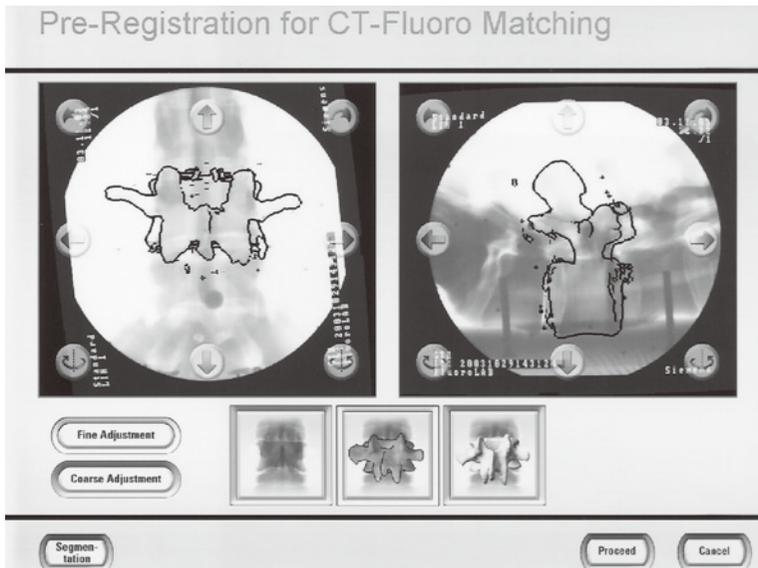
Pre-registration for CT-fluoro matching. Segmented vertebra is positioned over AP and lateral fluoroscopic images. Matching segmented vertebra as closely as possible to corresponding vertebra in fluoro image ensures best possible registration accuracy.
